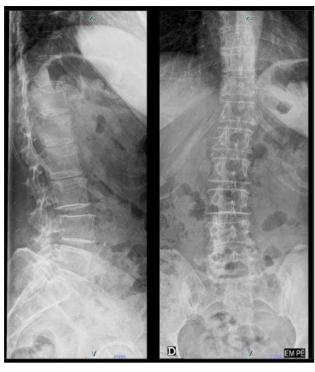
Plain AP and lateral spine radiography's
